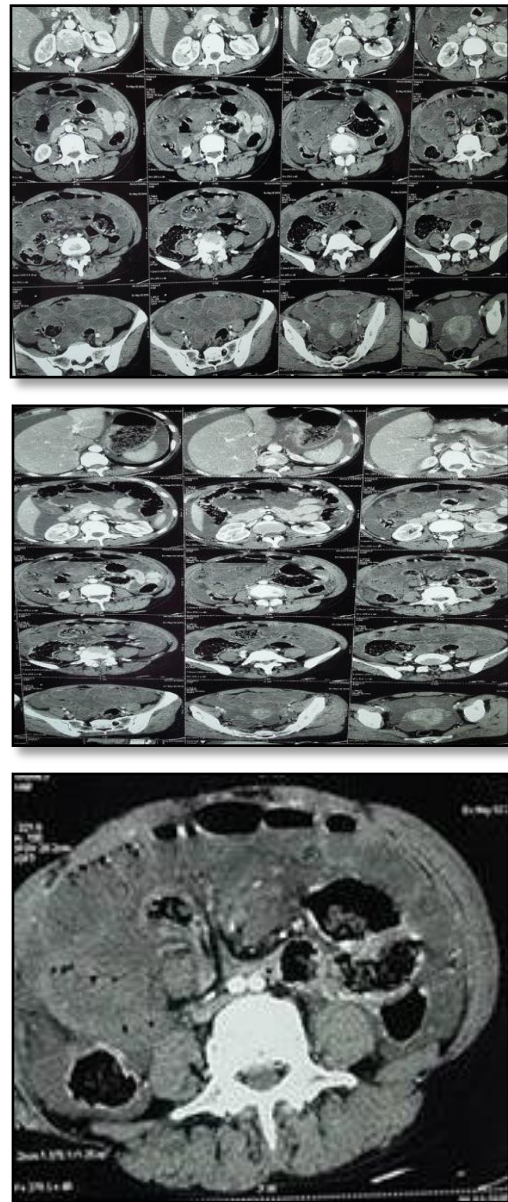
CT showing the “whirl” sign.
